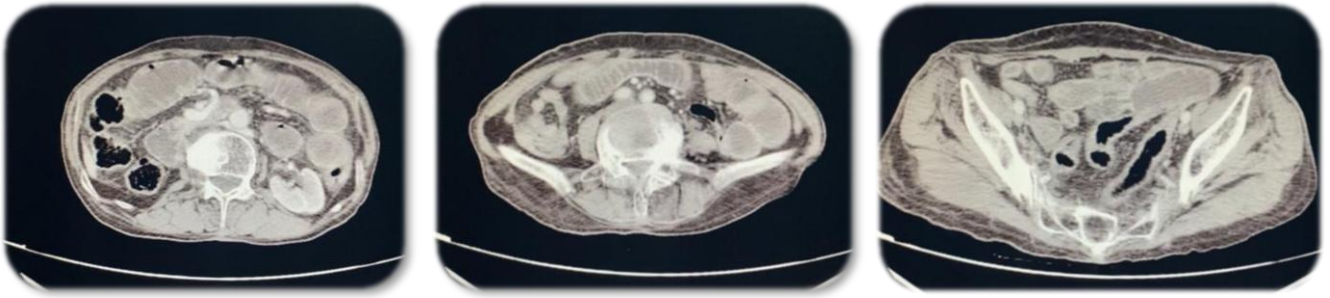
Abdomino-pelvic CT scan(cross-section): bowelocclusion
